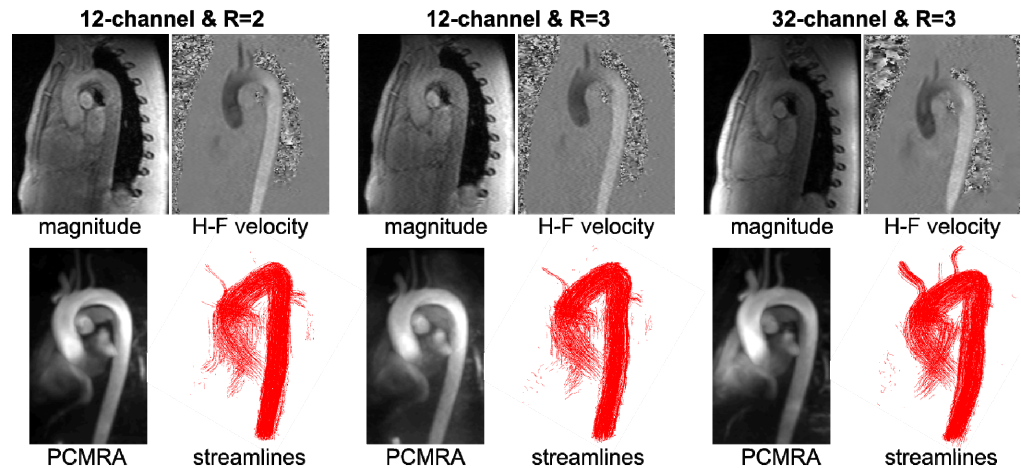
4D flow-sensitive MRI in a 26 years old volunteer: magnitude and head-foot velocity (sagittal plane), phase-contrast MR angiography (maximum intensity projection) and streamlines.
